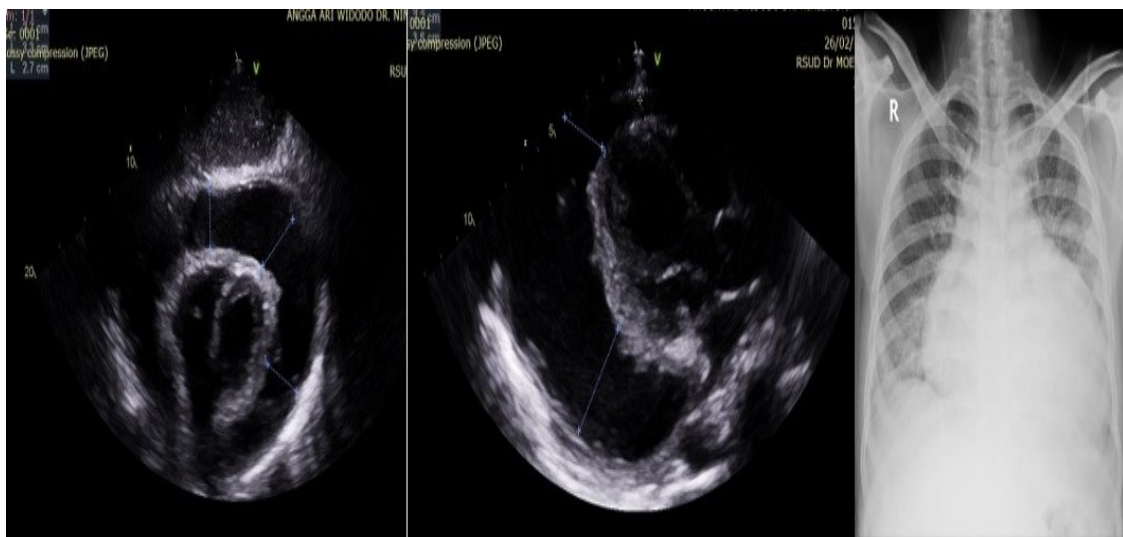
Transthoracic Echocardiography and Chest X-Ray of Patient With Pericardial Effusion
